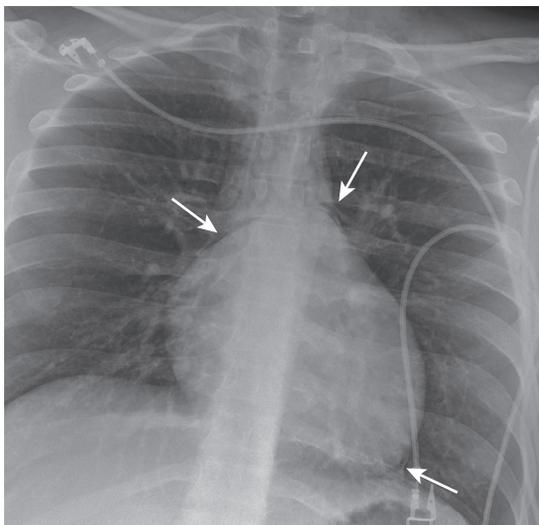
Portable chest x-ray demonstrating gas along central pulmonary arteries as well as around the cardiac apex (arrows). Pericardial insertion is along underside of aorta, limiting gas going around the aorta within the intact pericardium.
